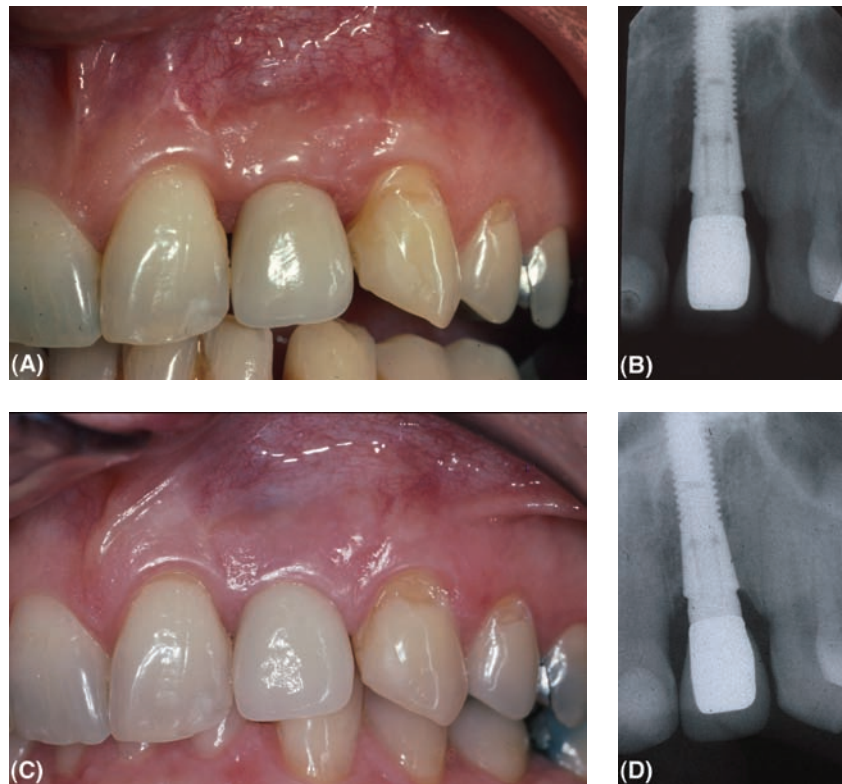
A series of photographs showing long-term maintenance of a single tooth implant restoration (Astra Tech) replacing a maxillary lateral incisor. (A) Clinical appearance of the left lateral incisor unit at cementation. (B) Radiograph of the completed restoration at cementation. The bone levels are at the top of the implant. (C) The improvement of the soft tissue profile and excellent healthy appearance six years later. (D) Maintenance of bone levels at the top of the implant after six years.
